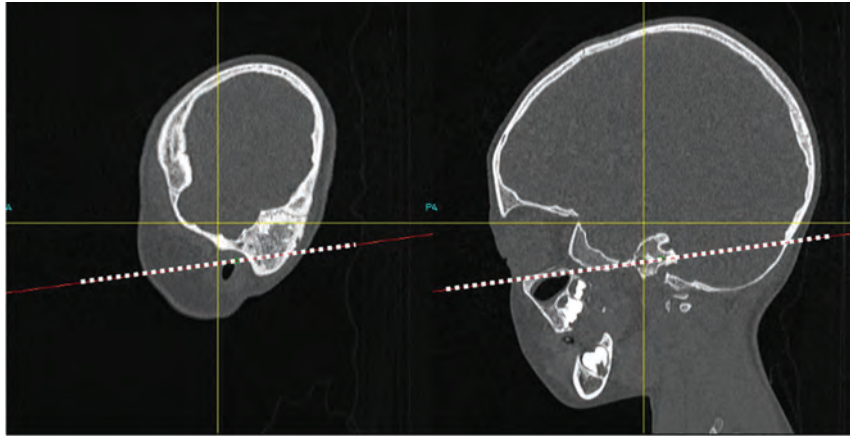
Multiplanar reconstruction CT of the facial bone in the sagittal view. The dotted line represents the Frankfort horizontal plane.
